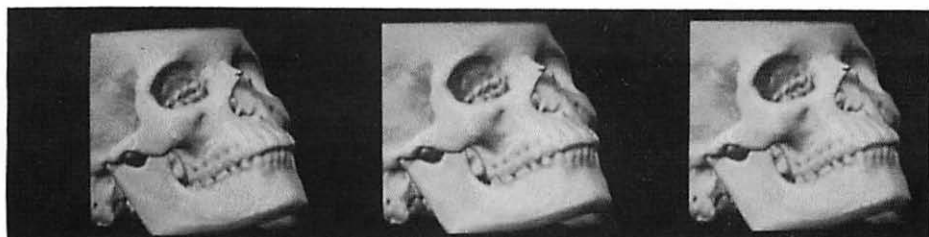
Photorealistic Rendering from CT Data
